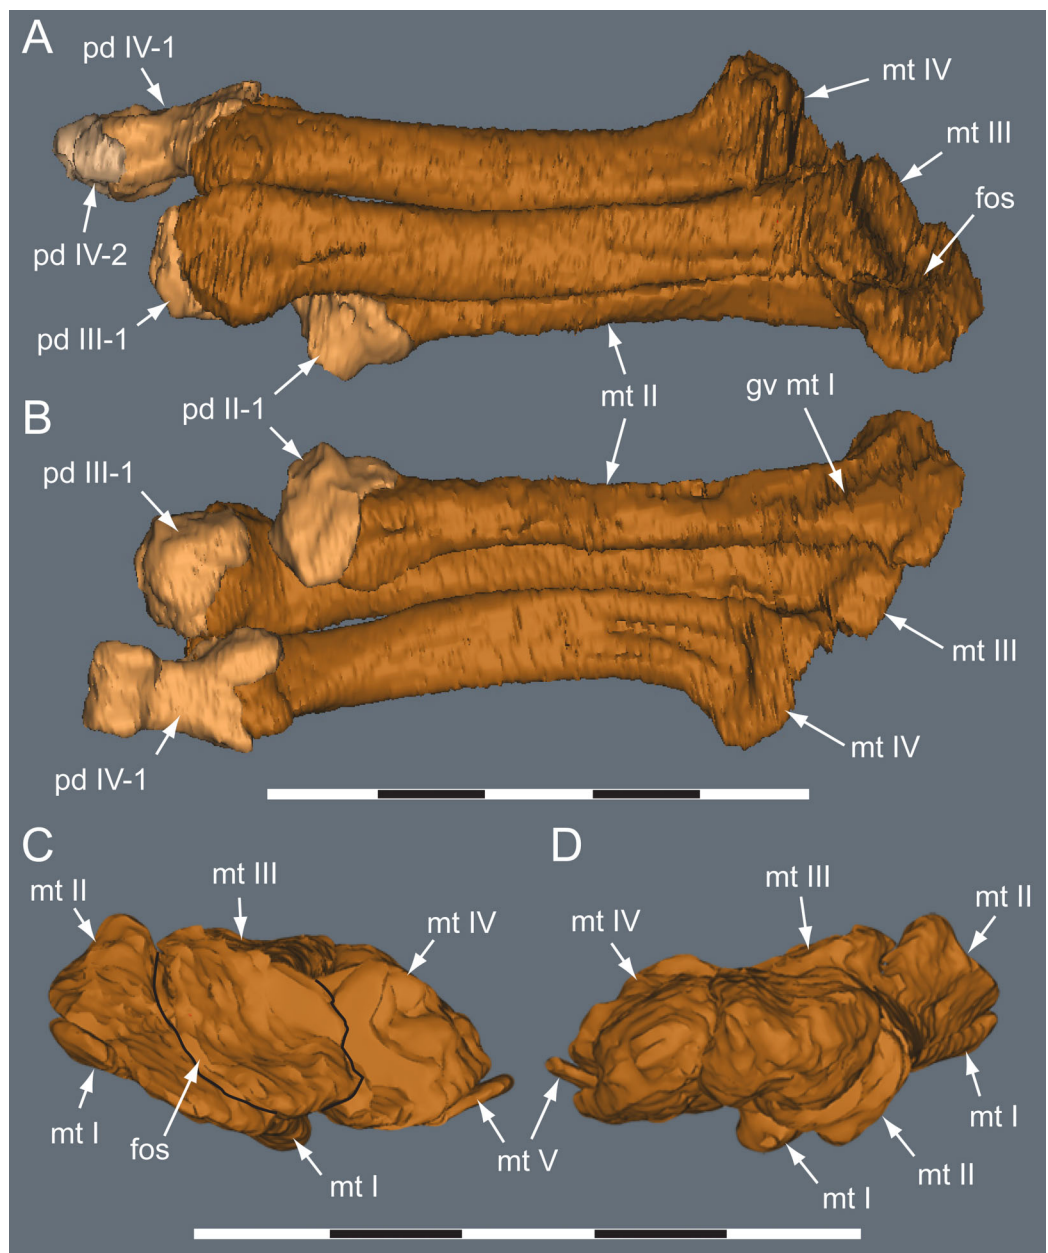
Diluvicursor pickeringi* gen. et sp. nov. holotype (NMV P221080), CT model of the right pes. A–B, pes with pedal digits I and V removed in: (A) dorsal; and (B) plantar views. C–D, partial metatarsus in: (C) proximal; and (D) distal views. Abbreviations: fos, fossa; gv mt I, groove for mt I; mt #, metatarsal position; pd #, pedal digit number and phalanx position. Scale bars equal 50 mm.
